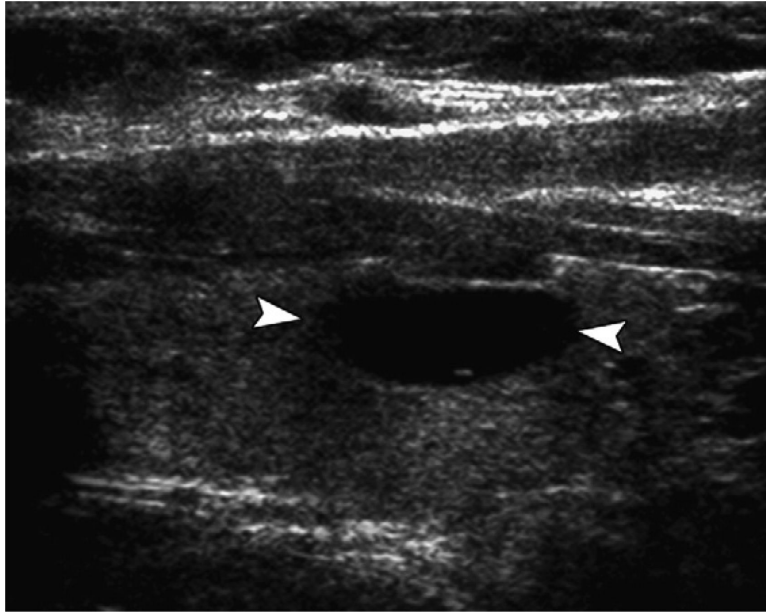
US image of a cystic thyroid nodule (*arrowheads*). (*Reproduced from Frates MC. Management of thyroid nodules detected at US: Society of Radiologists in Ultrasound consensus conference statement. Radiology 2005;237:794–800; with permission.*)
